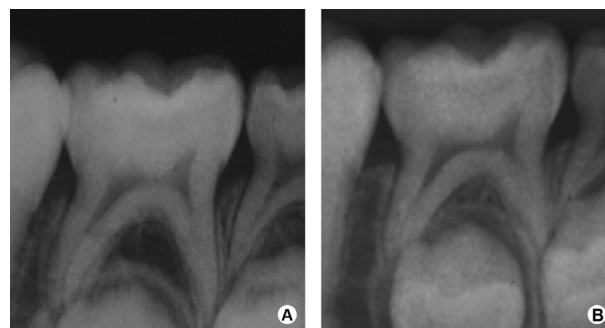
Radiograph of carious lesion in primary mandibular right second molar (NLG) at baseline (A) and 12-month follow-up period (B). A increase of area of caries was observed at final evaluation.
